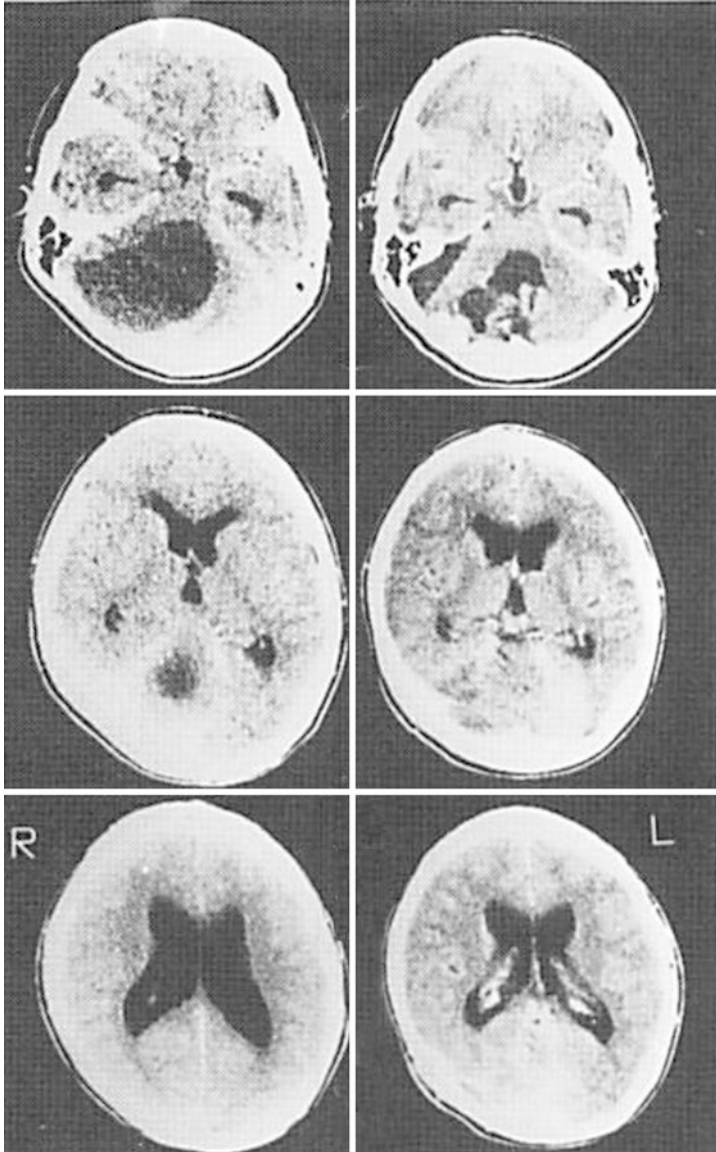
Pre- and 13 days after surgical CT scan. This finding reveals the original tumor showed right side dominance and wider resection of tumor was necessary in the right hemisphere [27]
